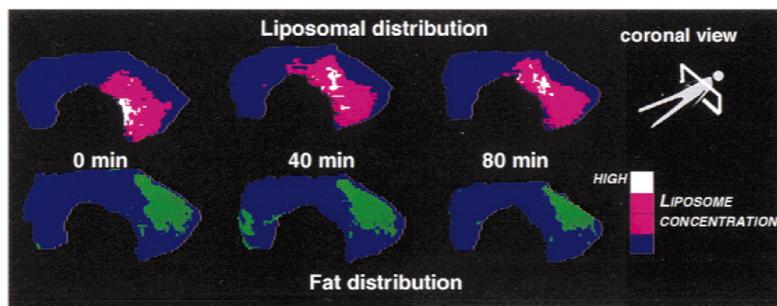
Maximum intensity projections obtained by MRI indicating poor gastric mixing of a liposomal formulation after a solid meal. Reprinted with permission of Springer [51].
